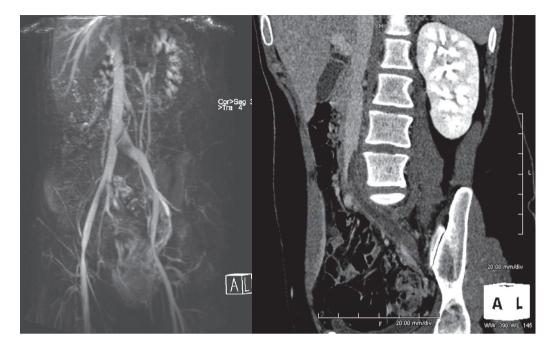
MR or CT-phlebography can give valuable information regarding vena cava and iliac veins.
